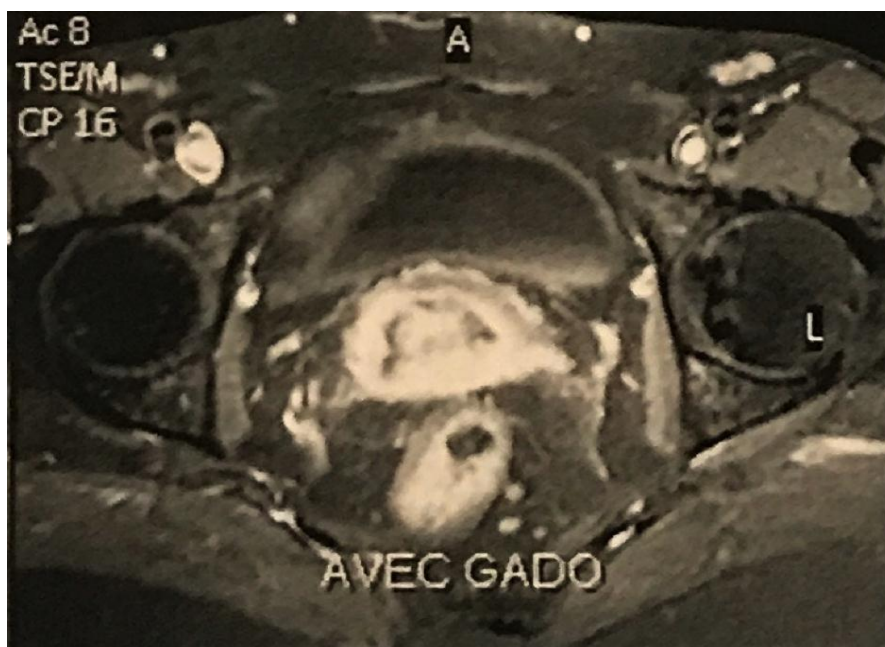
Axial T1 fat-suppressed post-gadolinium magnetic resonance imaging showing homogeneous enhancement of the cervical mass.
